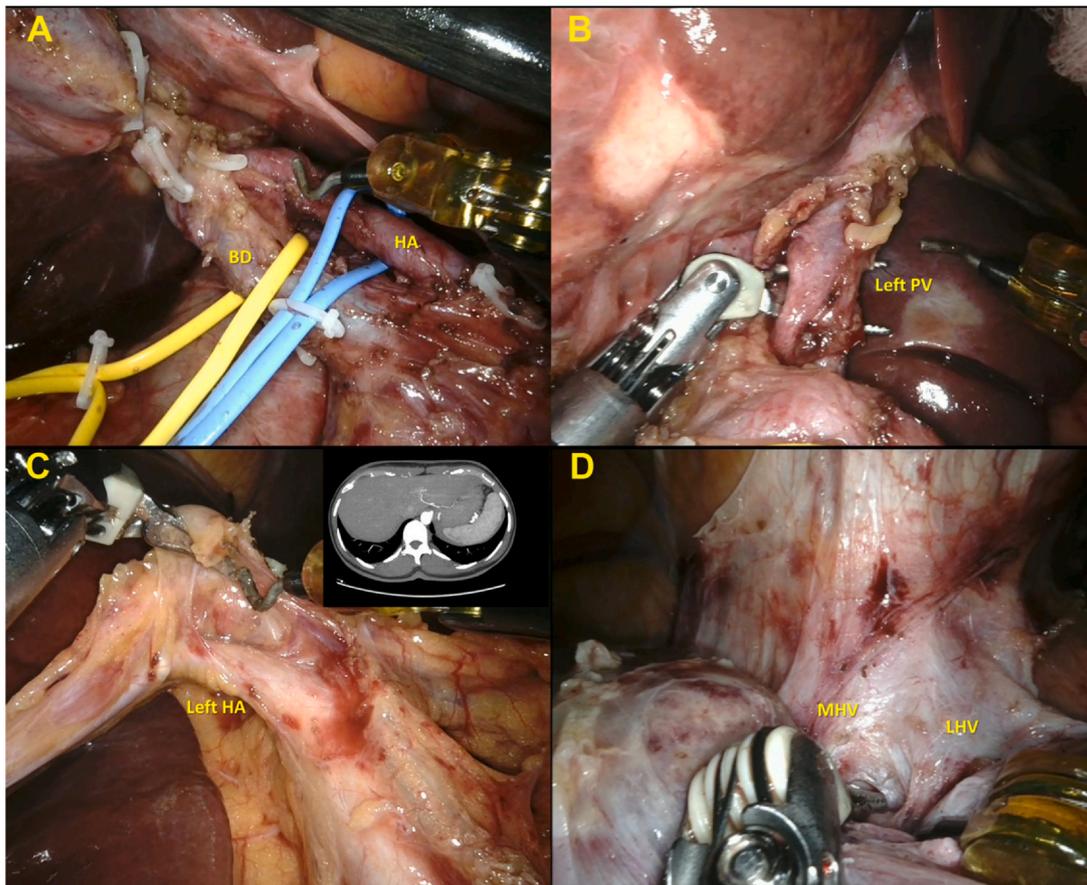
Robotic left trisectionectomy with lymphadenectomy and Roux-en-Y hepaticojejunostomy. A, Intraoperative view after lymphadenectomy. B, The intraoperative view shows the dissection of the left PV. C, The intraoperative view shows the dissection of the left HA originating from the left gastric artery. In the picture: CT scan of the arterial phase showing the left HA originating from the left gastric artery. D, Intraoperative view showing the dissection of the MHV and LHVs. BD, common bile duct; CT, computed tomography; HA, hepatic artery; LHV, left hepatic vein; MHV, middle hepatic vein; PV, portal vein.
